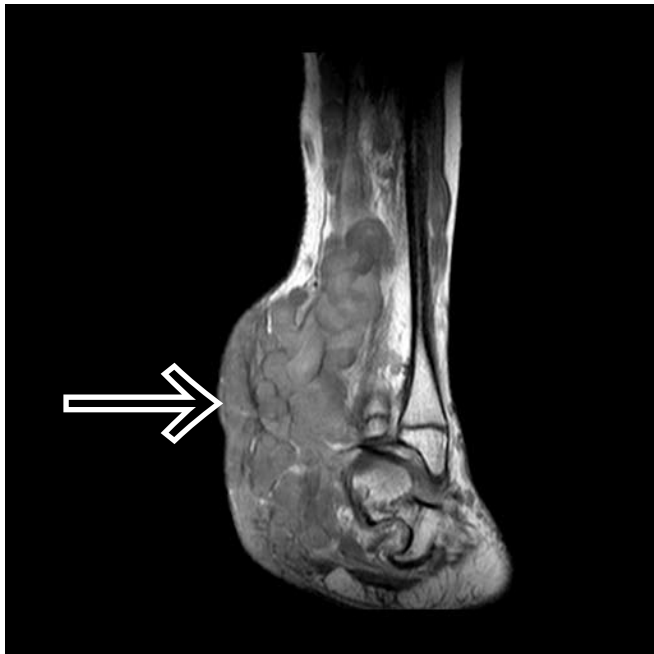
Coronal T1-weighted image of the distal lower limb showing poorly delineated multiple tortuous worm-like masses typical of a plexiform neurofibroma (courtesy of Dr Z Ebrahim).
